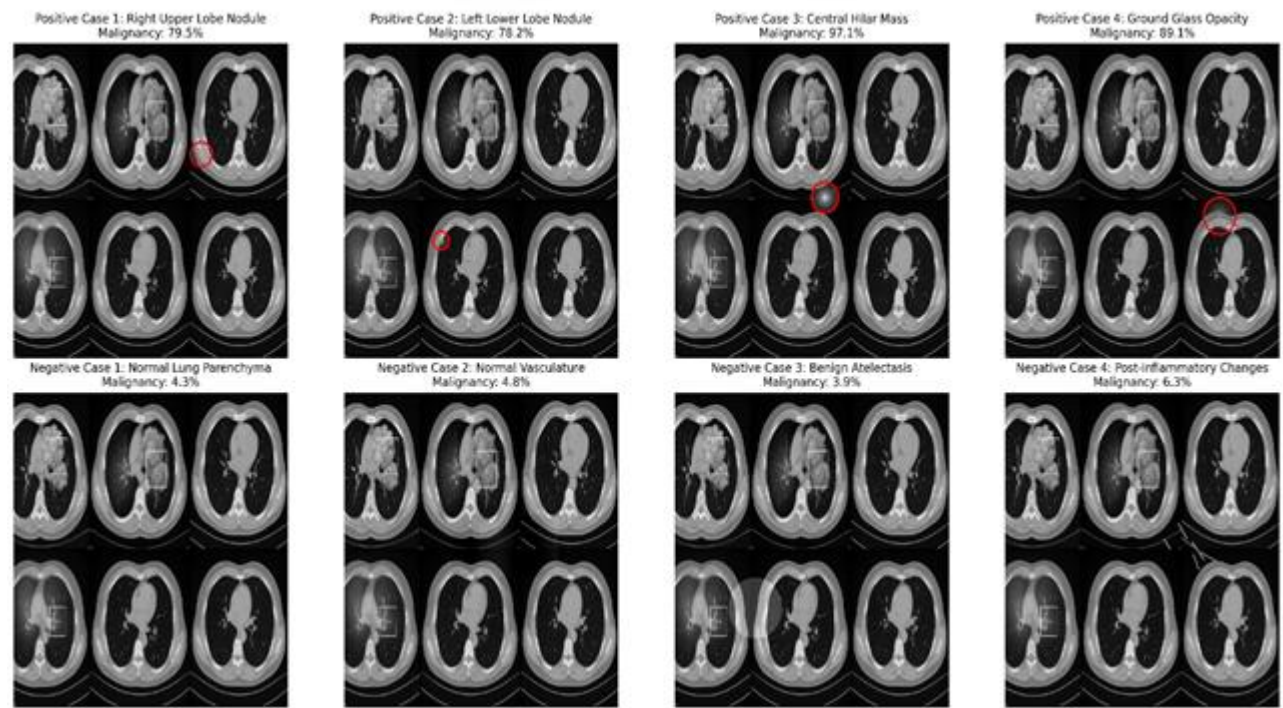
Visual examples of lung tumor detection using the proposed LungDxNet model, distinguishing among cancerous, non-cancerous, and normal lung CT scans.
